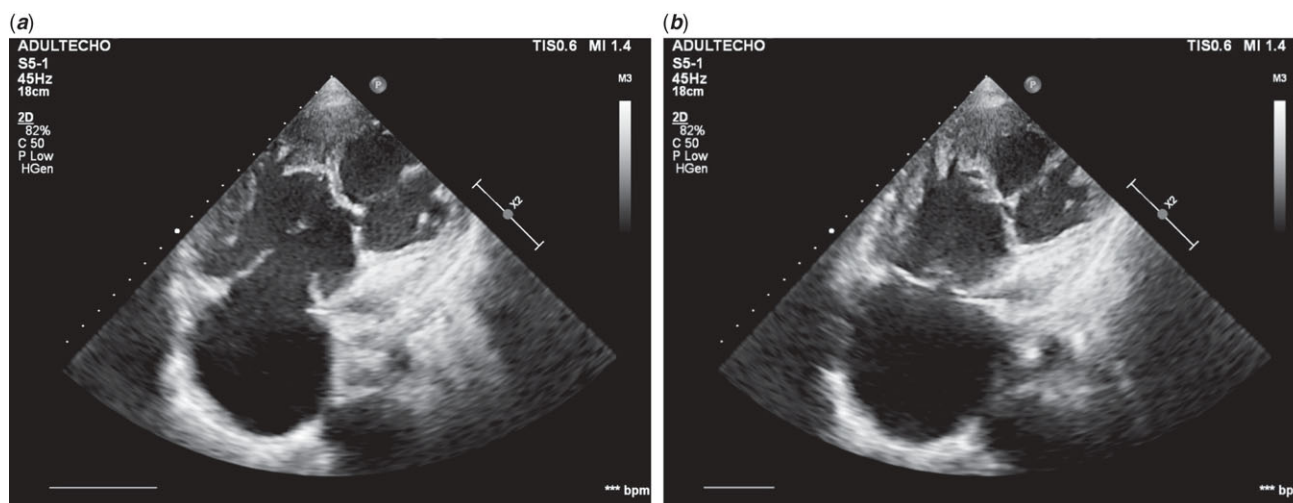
(a and b) Echocardiography, four-chamber view: diastole/systole (before levosimendan administration) shows significantly impaired single ventricle function.
